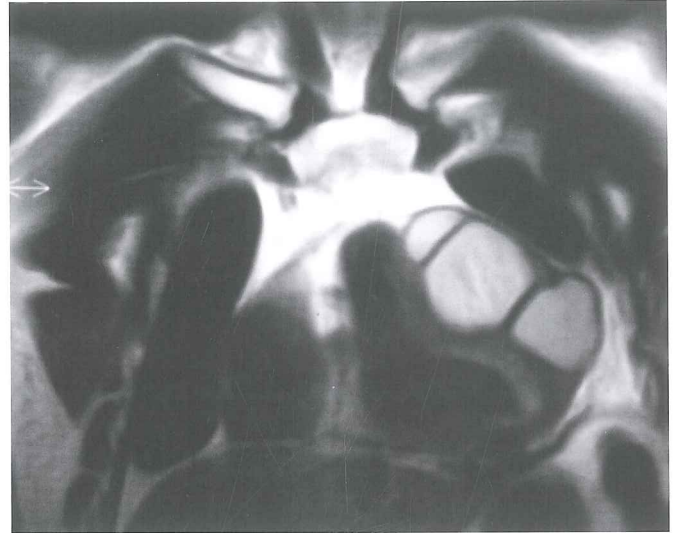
FFE T1 weighted MR imaging of the chest demonstrated the triloculated pericardial hydatid cyst extending from the level of the main pulmonary artery to down, in front of the right and left ventricular cavity with external compression.
